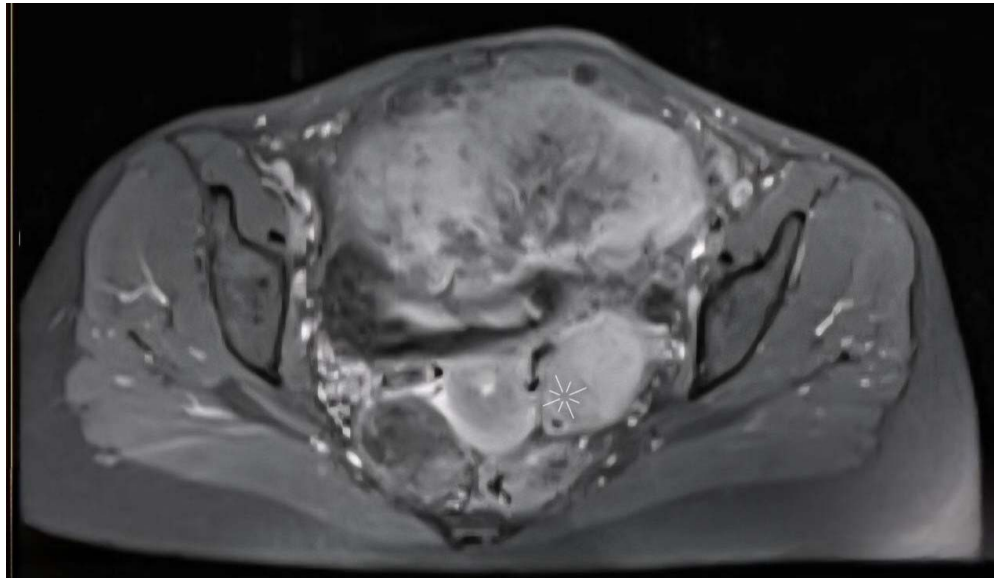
Post-contrast fat-suppressed T1-weighted image showing a well-defined, avidly enhancing solid mass adjacent to a left ovarian follicle (*), suggesting ovarian origin.
